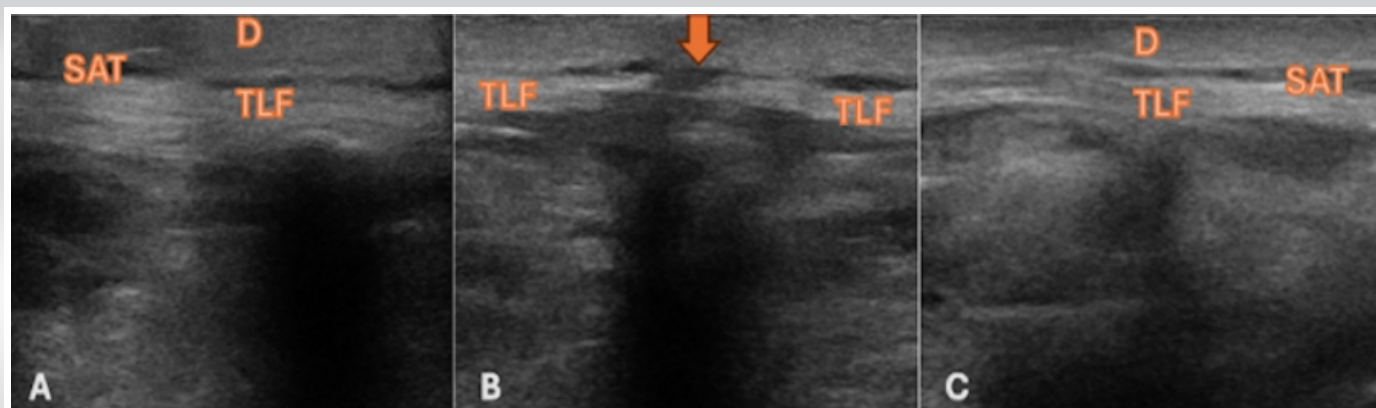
Ultrasound evaluation of the thoracolumbar fascia. Transverse sonograms demonstrate: (a) Preserved, thick, and continuous TLF obtained at the L1 level; (b) The L3 level demonstrating marked thinning of the thoracolumbar fascia at the midline (arrow), with the right and left fascial layers appearing separated, indicating a localized defect of normal fascial architecture; (c) Resumed thick and continuous TLF at the L5 level. TLF: Thoracolumbar fascia, L: Lumbar vertebrae, D: Dermis, SAT: Subcutaneous adipose tissue.
